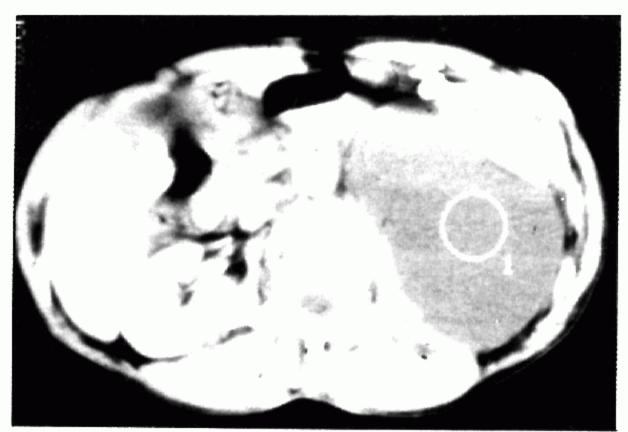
Computed tomogram shows a large cystic mass in the left retroperitoneal space with 22.5 Hounsfield unit. The left kidney is markedly displaced anterolaterally, without evidence of hydronephrosis.
